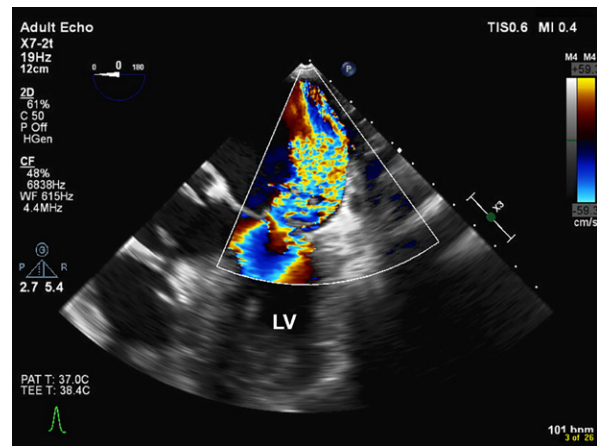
Transesophageal echocardiogram (mid-esophageal 4-chamber view in color-flow Doppler mode) shows torrential mitral regurgitation.
